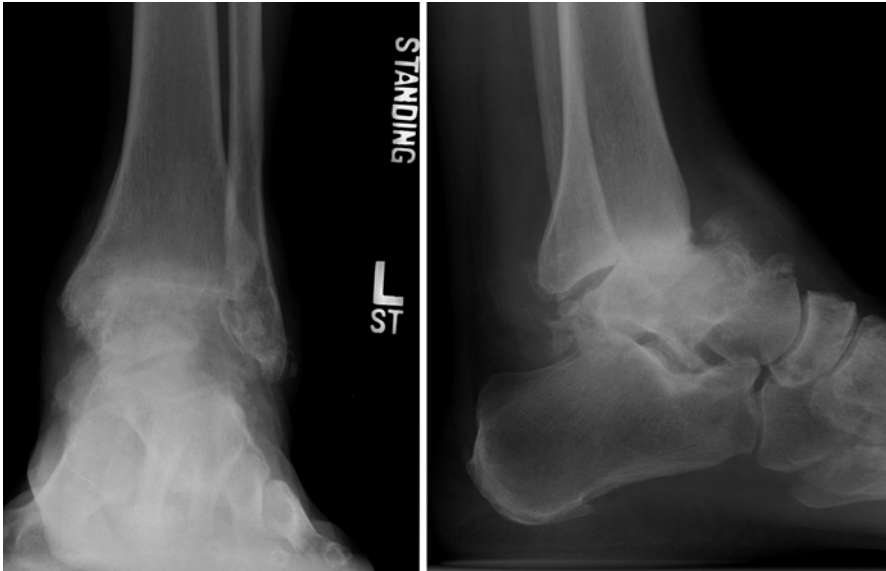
AP and lateral WB views of a patient with end-stage ankle arthritis. Note the significant anterior subluxation of the talus on the lateral radiograph which must be addressed intraoperatively
